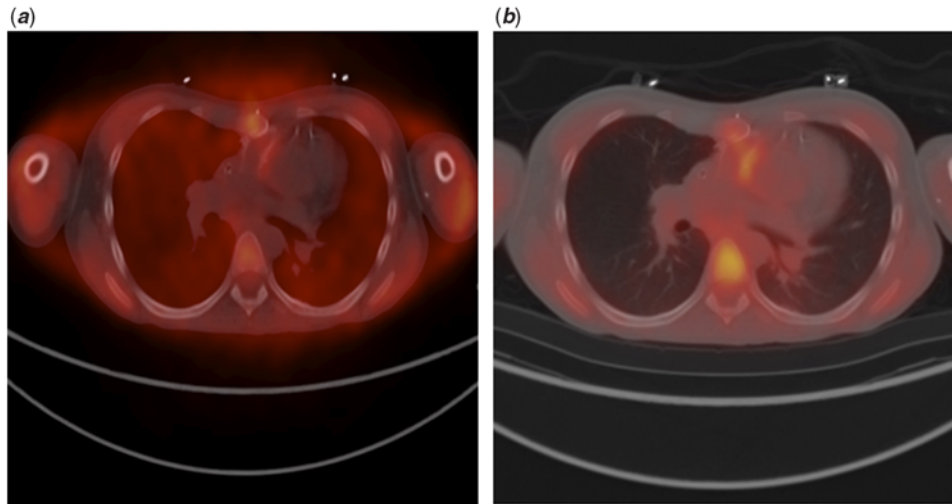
(a) Case 2 – ^{18}F FDG-PET/CT showing mild metabolism at sternotomy, likely due to post-operative changes. Mild hypermetabolism involving the pulmonary artery to right ventricle conduit. (b) Case 2 – Attenuated ^{18}F FDG-PET/CT image, which corrects for areas of differing tissue density across the image, shows persistent hypermetabolism in the walls of the pulmonary artery to right ventricle conduit. The enhancement of the vertebrae is due to normal bone marrow activity. ^{18}F FDG-PET/CT= ^{18}F -fluorodeoxyglucose positron emission tomography in combination with CT.
